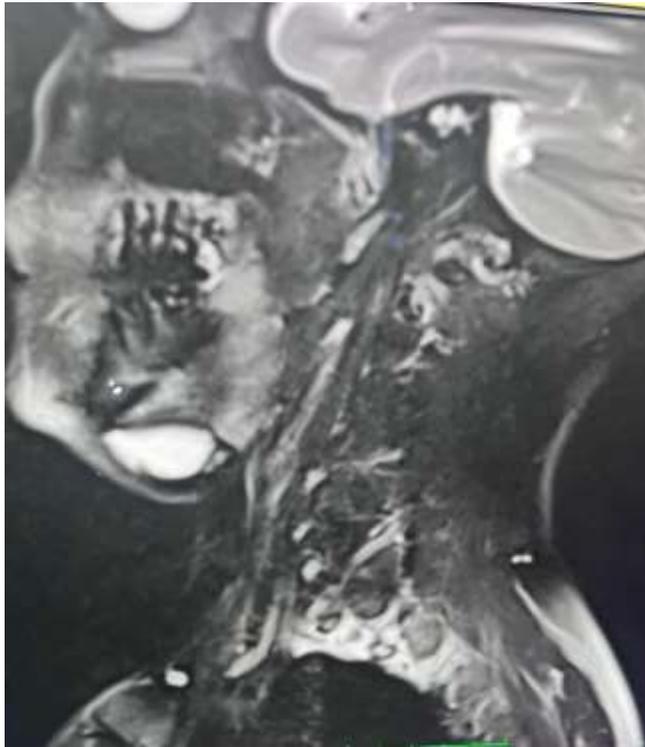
MRI showing saggital section of a cystic lesion with thin T2 hypointense, non-enhancing capsule seen in right sub mandibular region, measuring approximately 35*15 mm in cross section.
